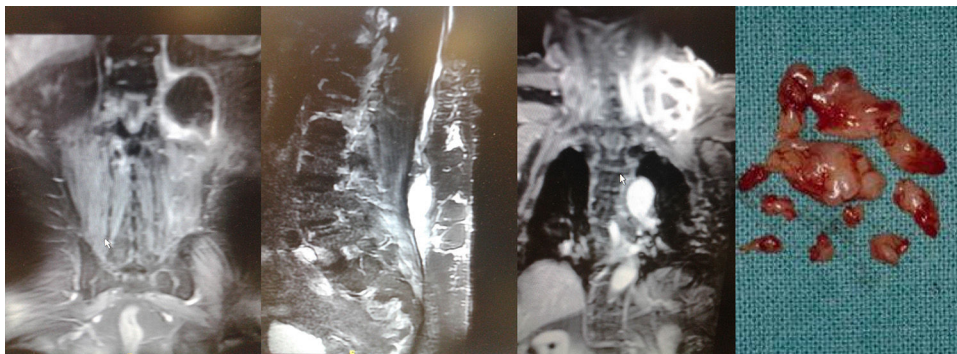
MRI image of the upward progression of the abscess collection in front of the left psoas muscle (station 1) at the superior paraspinal (station 2) and ipsilateral supraclavicular pretrapezial (station 3) areas, with appearance of the samples withdrawn.
